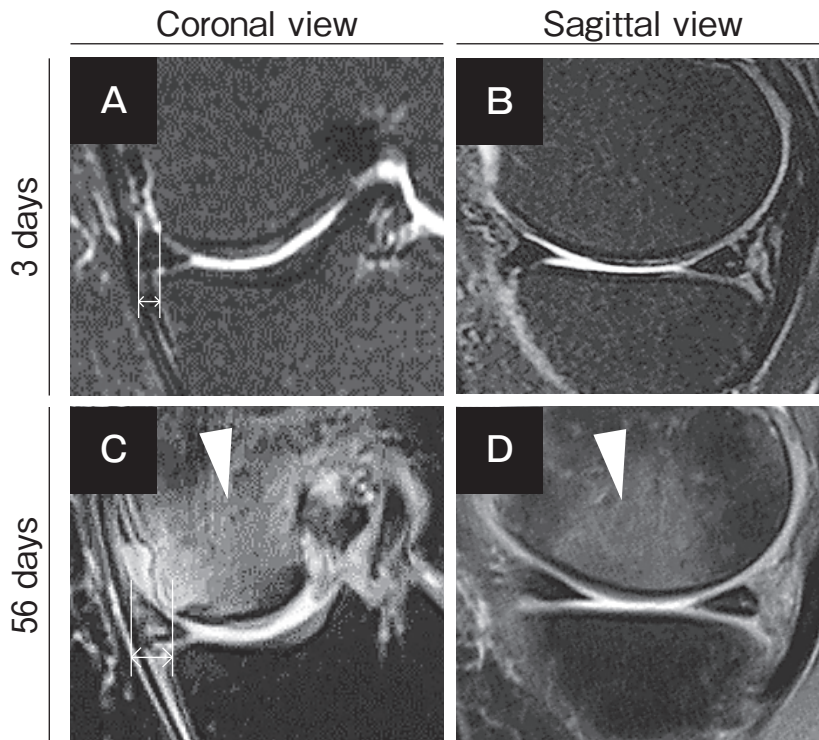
MRI of patients who underwent MMPRT repair. (A, B) Images 3 days after MMPRT with no apparent BME and moderate MME (3.6 mm). (C, D) Images 56 days after MMPRT with outstanding BME (arrowhead) and MME progression (5.1 mm).
